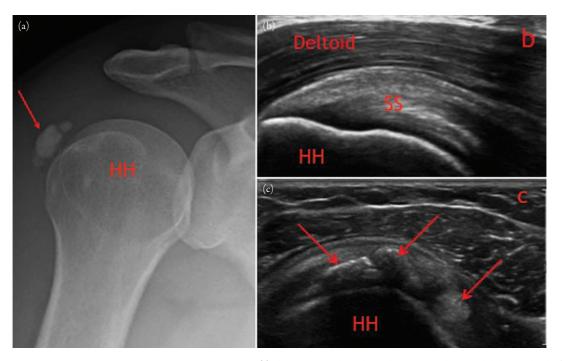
Calcific tendinosis of the supraspinatus tendon. Panel (a) shows an AP shoulder radiograph with smooth lobulated calcifications (arrow) projecting over the soft tissues near the lateral aspect of the humeral head. Panel (b) shows a grayscale sonographic image in longitudinal plane of the normal supraspinatous tendon (SS), while Panel (c) shows a grayscale longitudinal image of the supraspinatous tendon with echogenic calcific deposits (arrows).
